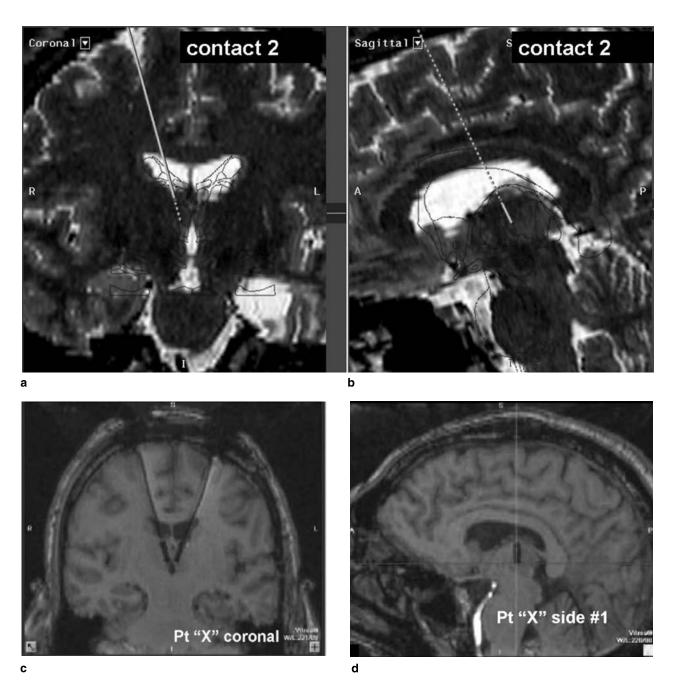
Thalamic anterior nucleus deep brain stimulation: (a) Coronal T2 MRI images of trajectory planning for placement of ANT DBS. (b) Sagittal T2 MRI images of trajectory and target planning for placement of ANT DBS. (c) Postoperative coronal T1 MRI revealing location of ANT DBS. (d) Postoperative sagittal T1 MRI revealing location of ANT DBS.
